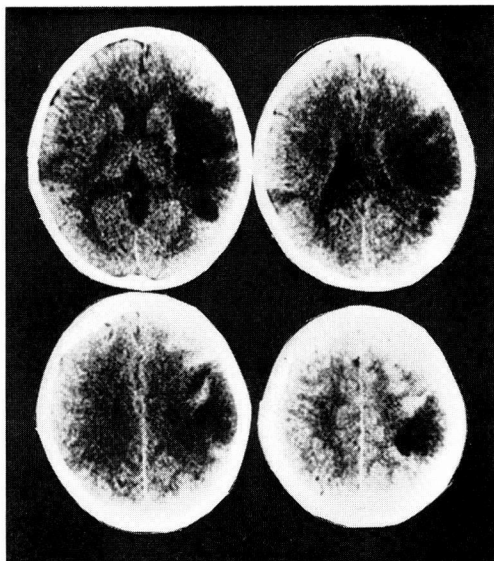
A CT scan of Case 1, demonstrating cerebral infarction in the right temporo-parietal regions.
